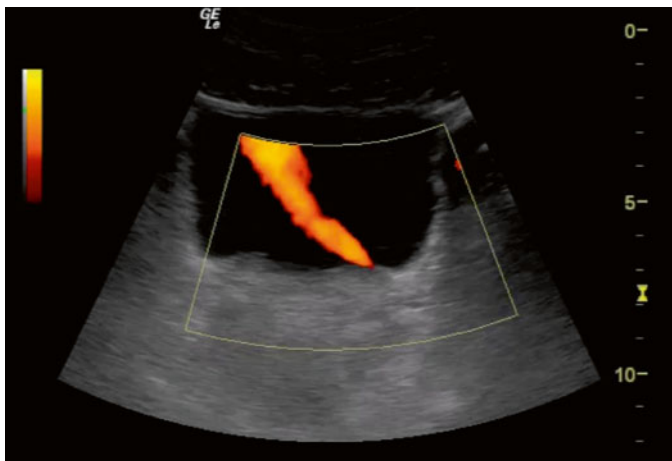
As urine enters the bladder, power Doppler visualizes a ureteral jet in this transverse view
